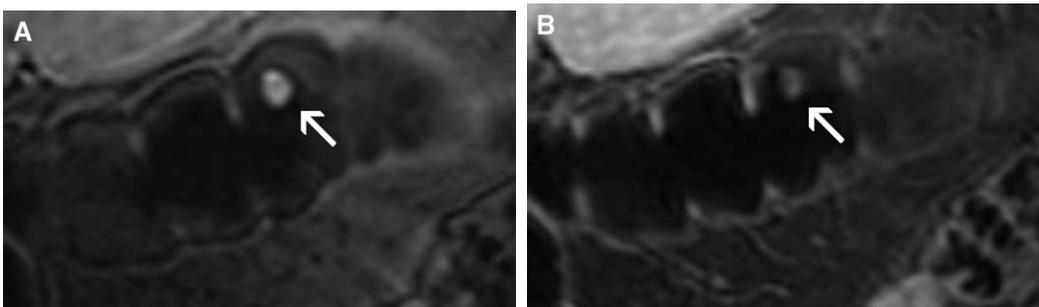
The acquisition of pre- (A) and postcontrast-enhanced (B) T1-weighted data allows a reliable differentiation between residual stool and polyps, because stool particles (arrow) already are of high signal intensity on the native scan and do not show any contrast uptake.
